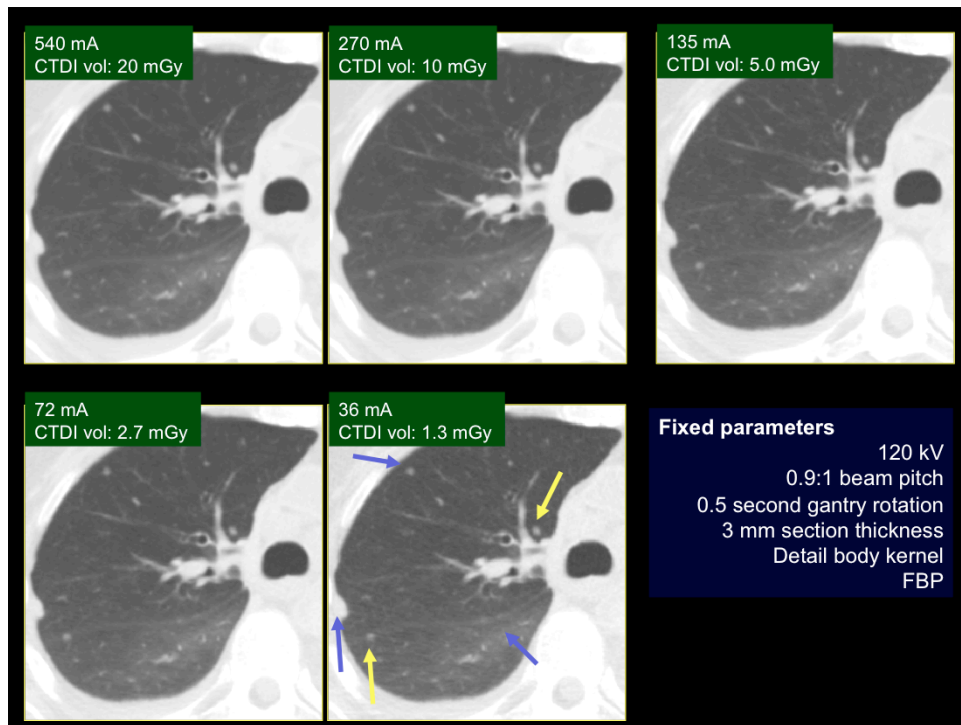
Post mortem chest CT of a 60 year old female (52 kg) with known diagnosis of metastatic papillary carcinoma at various tube current levels. Low radiation dose image (18 mAs, CTDIvol: 1.3 mGy) show right pleural and pulmonary nodules as well as ground glass opacities (arrows) in right lower lobe.
